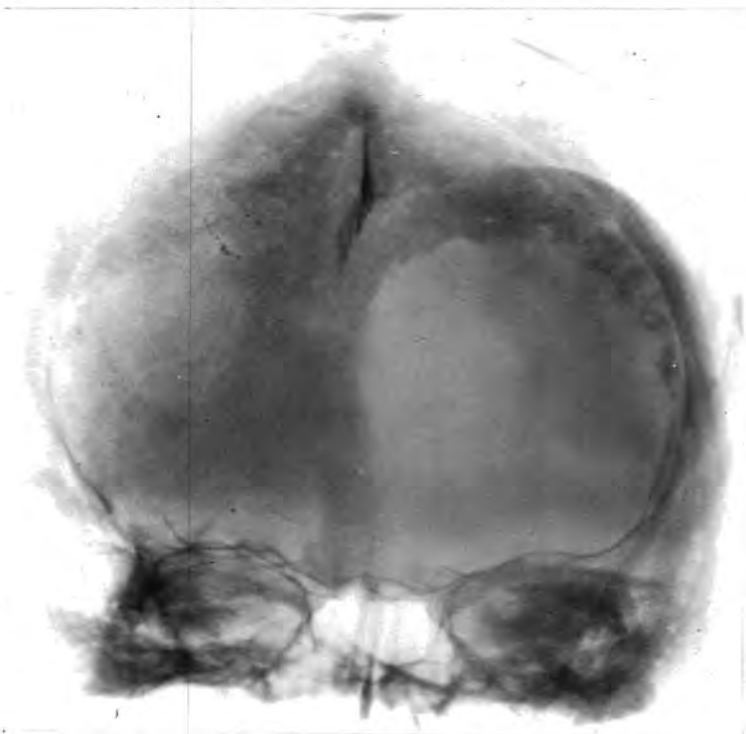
CASE SEVEN. X-ray of skull, A.P. view, showing large left frontal myeloma.
